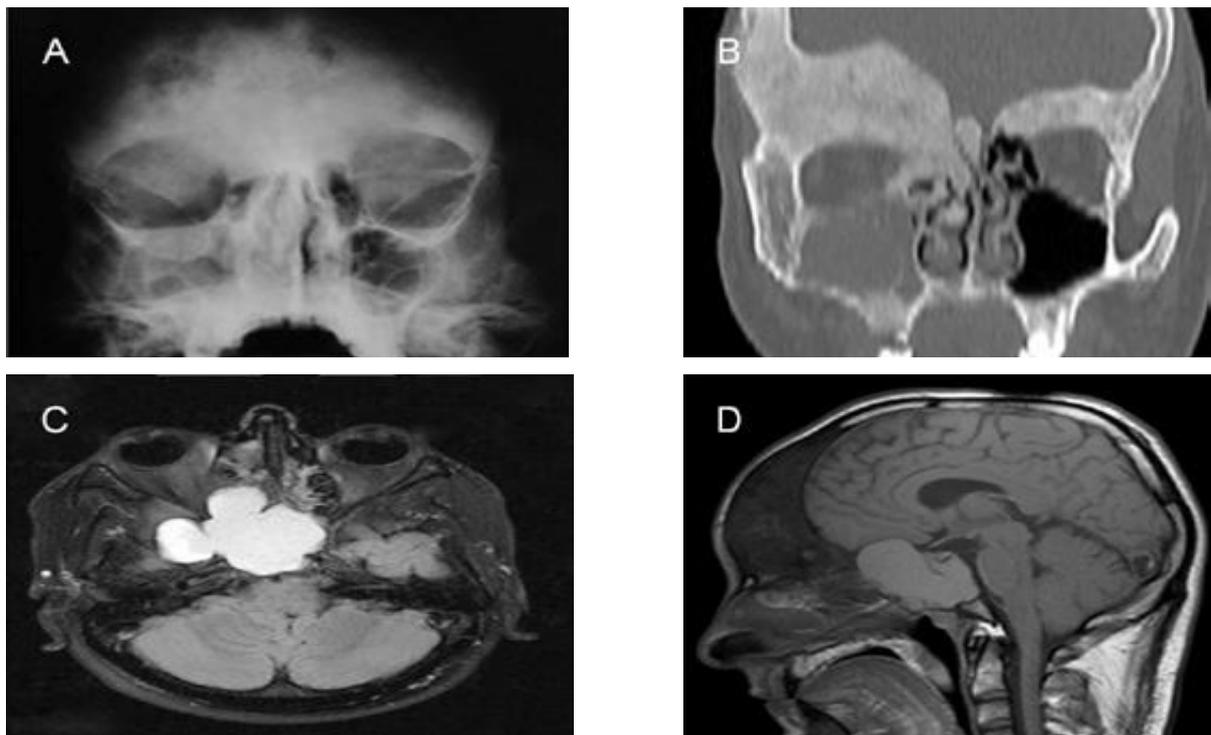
Orbitofrontal and sphenoidal fibrous dysplasia: A). Radiographic appearance characteristic aspects of “ground glass”; B). CT scan images; C) MRI scan images: homogeneous well defined cystic lesion (57/56/41mm) located in the sellar, suprasellar and parasellar areas, predominantly on the right side, extending in the anterior cranial fossa, with compressive effect on the optic chiasm; D). T1-weighted MRI scan showing the large cyst and frontal dysplasia (Costea *et al.*, 2015c).
